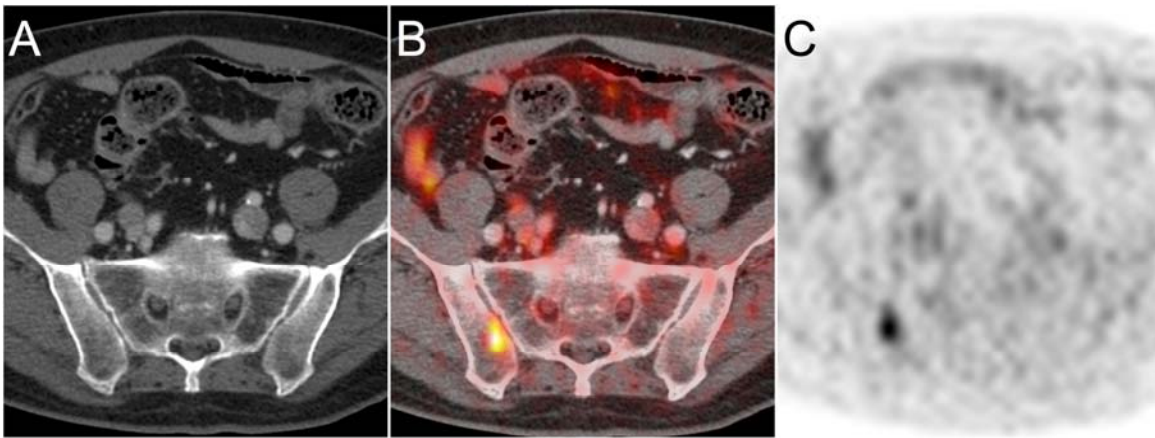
Example of a major change in management. 69-year-old man with biochemically recurrent prostate cancer, who was originally treated with a radical prostatectomy in 2014, then with salvage radiation therapy in 2015. He presented for ^{68}Ga -PSMA-11 PET with a PSA of 0.059. Imaging demonstrated a single PSMA positive lesion in the right iliac bone (C) with no correlate seen on CT (A, fused image B). The patient was converted from active surveillance to radiation combined with ADT therapy.
